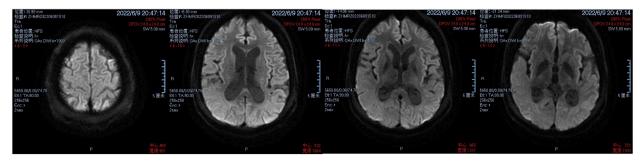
MRI showed abnormal signals in multiple regions of the brain.
